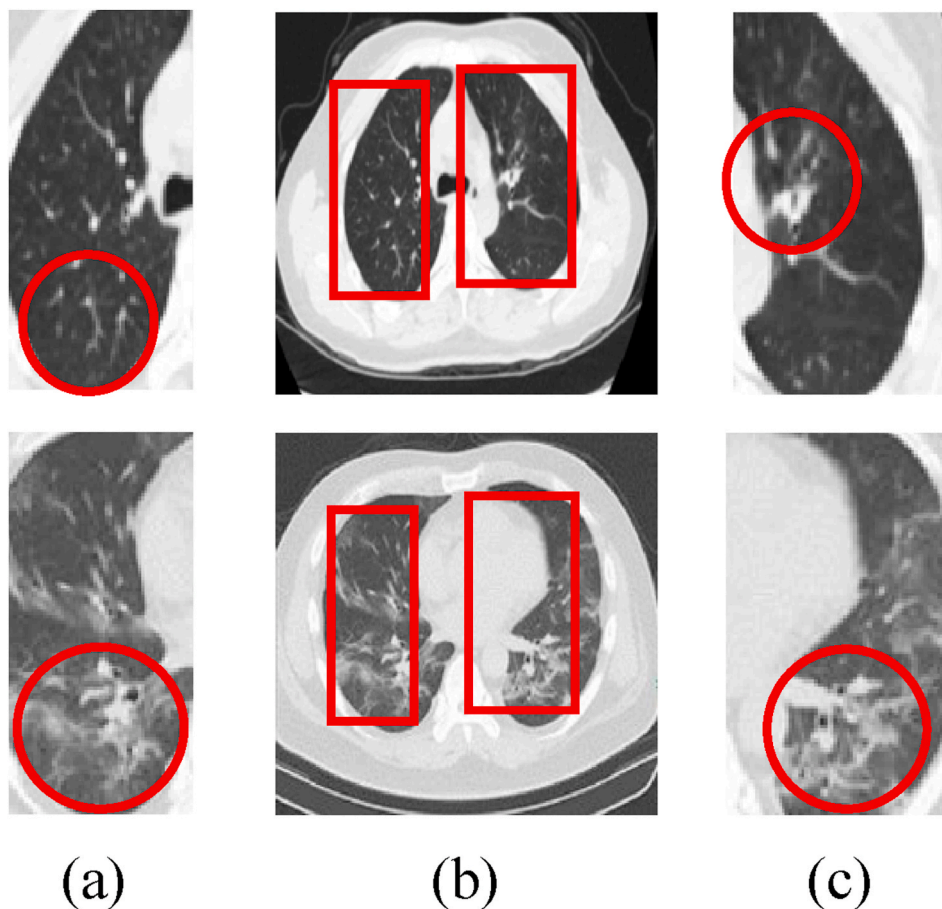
The ROI extraction. (a) The ROI of left lung; (b) The extracted region of the lung CT image; (c) The ROI of the right lung.
